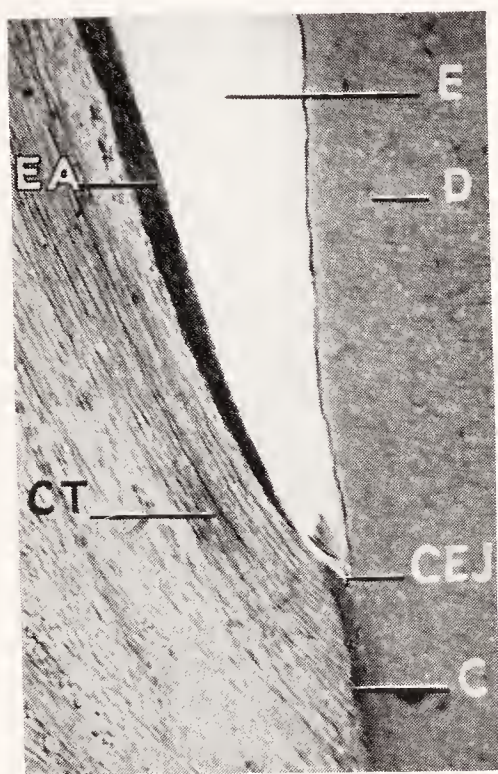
High magnification of the cemento-enamel junction in Figure 265. *D*, dentin; *E*, enamel space; *CEJ*, cemento-enamel junction; *EA*, epithelial attachment to the enamel; *CT*, connective tissue; *C*, cementum. Notice the absence of round-cell infiltration in the subepithelial connective tissue.
